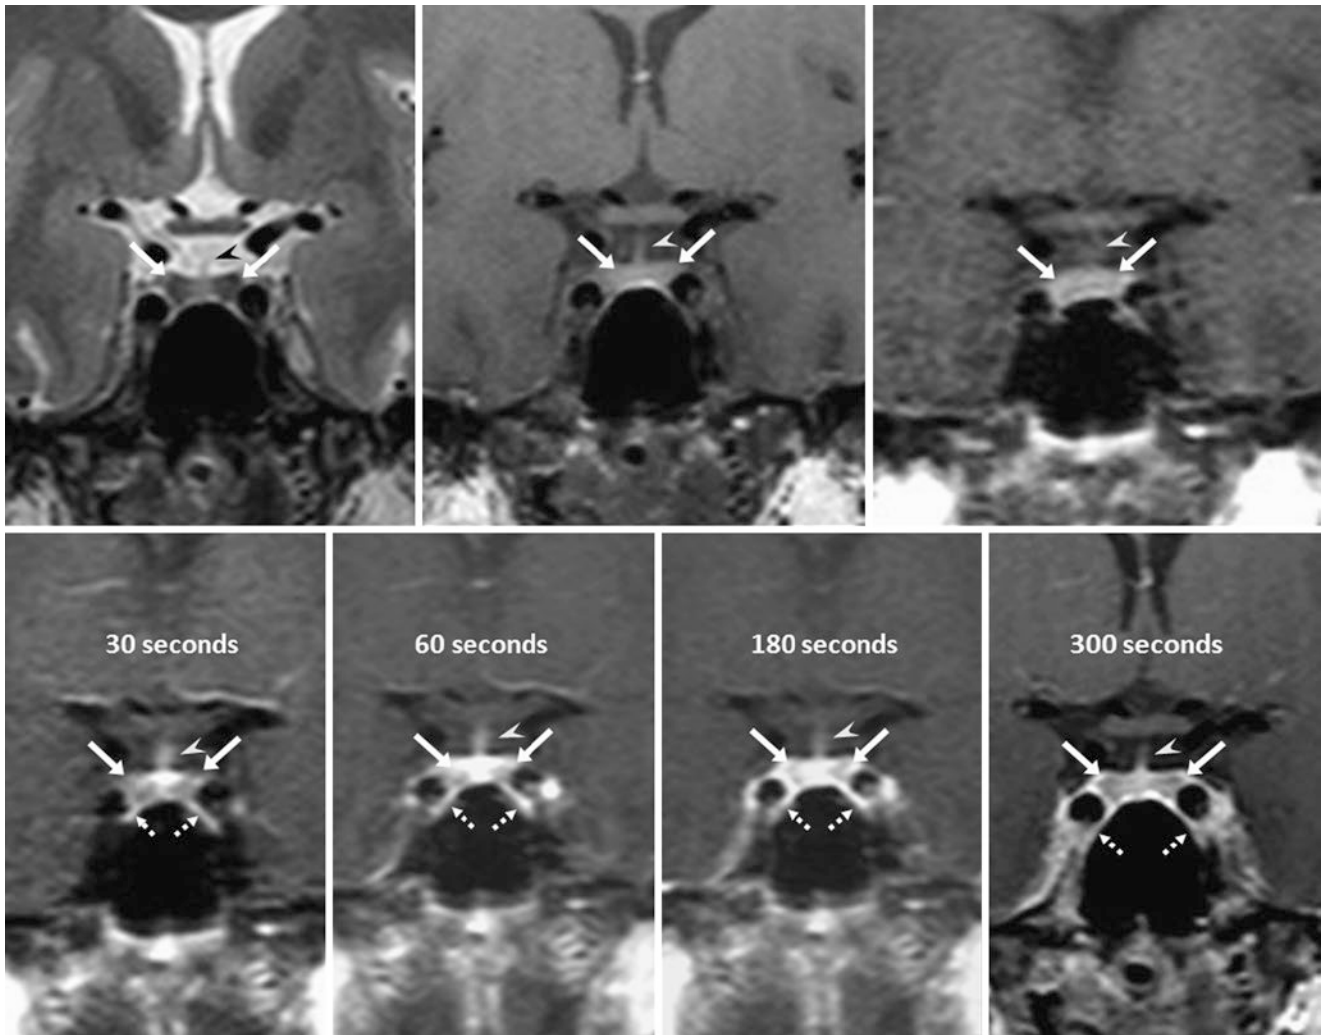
Normal lateral anterior lobe enhancement with persistent hypointensity. In a 22-year-old hypernatremic male, the lateral aspects of the anterior lobes (*arrows*) are hypointense prior to contrast on 3 T MRI coronal T2WI (*top left*) and T1WI (*top middle*); the MRI was interpreted
